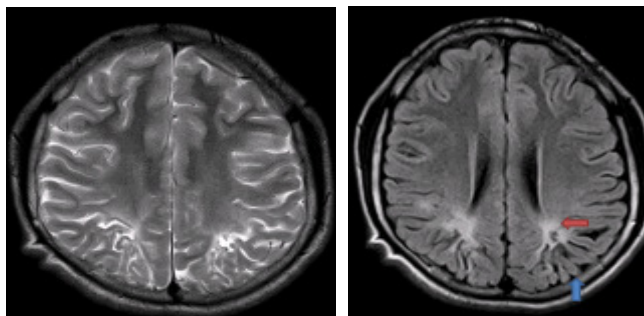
Axial MR T2 W & FLAIR images demonstrating high-intensity signal from the bilateral posterior parietal/occipital regions. The high-intensity signal is involving the white matter with a typical distribution at the arterial border zone (red arrow). The shrunken cortex has a peculiar pattern in which deep portions of gyri are more affected than superficial portions, creating mushroom shaped gyri (blue arrow)
